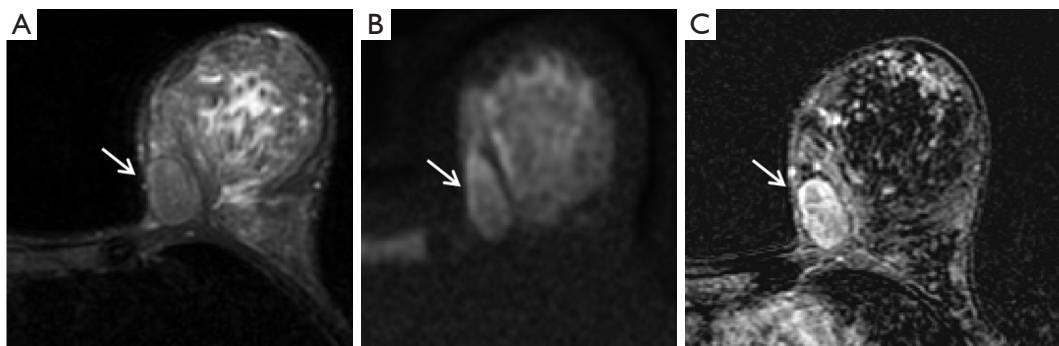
Fibroadenoma in a 40-year-old woman. The mass (white arrows) showed low signal intensity on T2WI with fat-saturation (A), intermediate signal intensity on DWI with b values of $1,000 \text{ s/mm}^2$ (B), in discordance with DWI-T2WI set in the decision rule by Kim *et al.* The lesion displayed oval shape, well-circumscribed margin, heterogeneous internal enhancement and plateau kinetics (C), with ADC values of $1.56 \times 10^{-3} \text{ mm}^2/\text{s}$. It was considered as malignant by the decision rules by Istomin *et al.* and Zhong *et al.*, and benign by Kaiser score and BI-RADS category. T2WI, T2-weighted imaging; DWI, diffusion-weighted imaging; ADC, apparent diffusion coefficient; BI-RADS, breast imaging reporting and data system.
